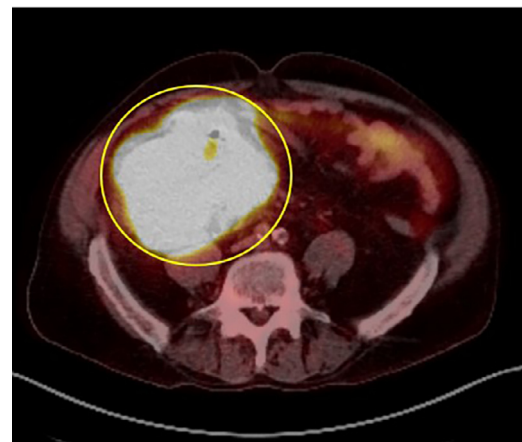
A 70-year-old male with a 1-month history of mild right lower quadrant pain and 24-pound weight loss. (A and B). Axial and coronal contrast-enhanced CT scans of the abdomen and pelvis demonstrated a 10.7 x 8.7 cm solid mass with possible early central necrosis. The mass extends to the terminal ileum.
